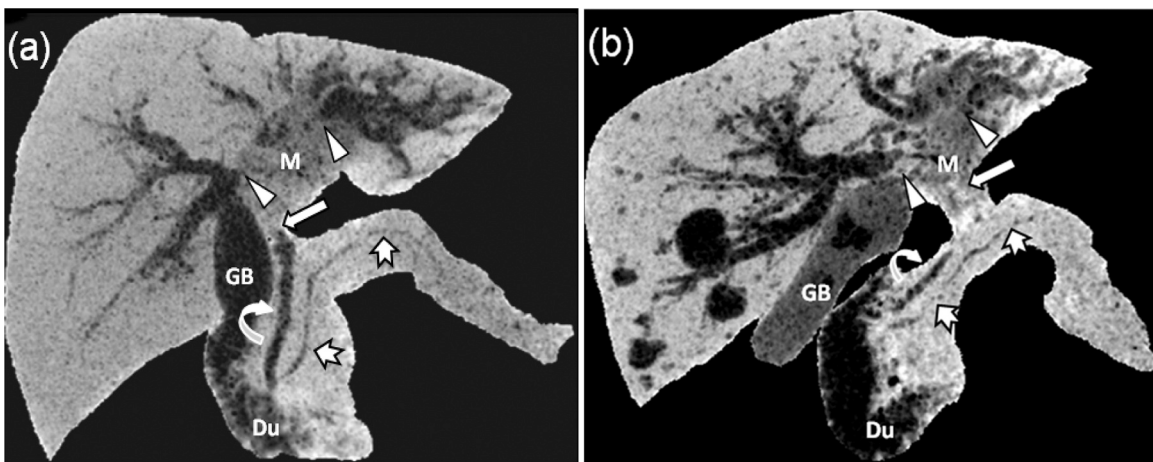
Intrahepatic ductal dilatation secondary to hilar cholangiocarcinomas confirmed by pathology. 3D nCTCP with MinIP images from SECT (A) in a 68-year-old female with a BMI of 20.54 and DECT (B) in a 65-year-old male with a BMI of 22.10. Comparisons of subjective image quality between DECT and SECT images demonstrate a slightly lower background noise (grade of 5 vs 4), sharper intrahepatic ductal margin (grade of 5 vs 4), and overall image quality (grade of 5 vs 4). Both CT sets depict that mass (M) involved the secondary confluence of both the right (arrowheads) and left hepatic ducts as well as common hepatic ducts (arrows). The nondilated common bile ducts (curved arrows) and duct segments of the pancreatic head and body (tailed arrows) are also shown. Du, duodenum; GB, gallbladder.
